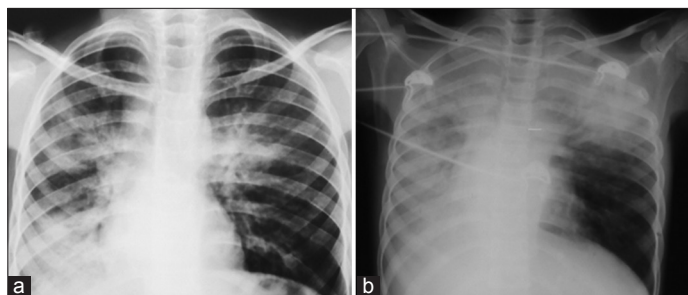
Chest X-ray. (a) On admission showing right lower lobe consolidation. (b) At 72 h showing progression of consolidation involving whole right lung and left upper lobe
